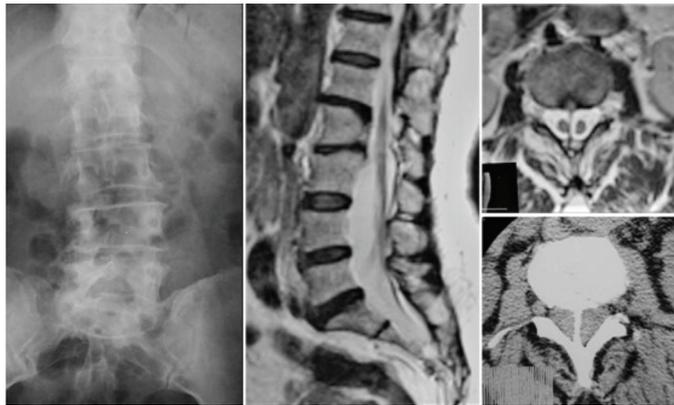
A 64-year-old female applied with complains of pain, numbness, weakness, neurogenic claudication and incontinence in legs after running. Plain X-ray revealed a bony spur at L2-L3 levels. CT showed a bony spur extending from the lamina of L2 through the midline of the spinal canal to the posterior margin of the L2-L3 disc space. MRI showed a bisection of the spinal cord and conus medullaris were tethered to L4 level
